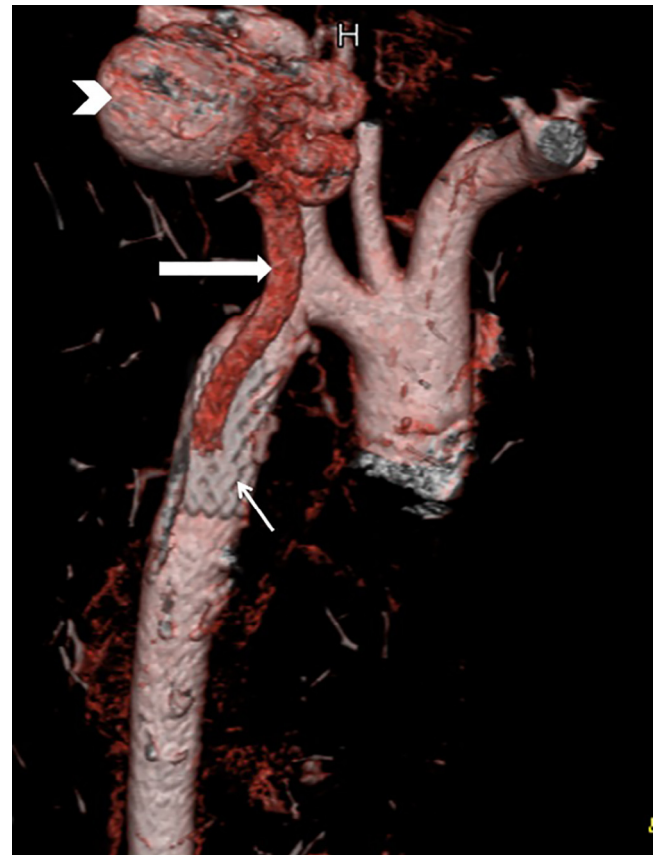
Angio-computed tomography 3 months after stenting. Three-dimensional surface reconstruction demonstrates the aneurysm patency (arrowhead) despite the stent (thin arrow) and the collateral (arrow).
